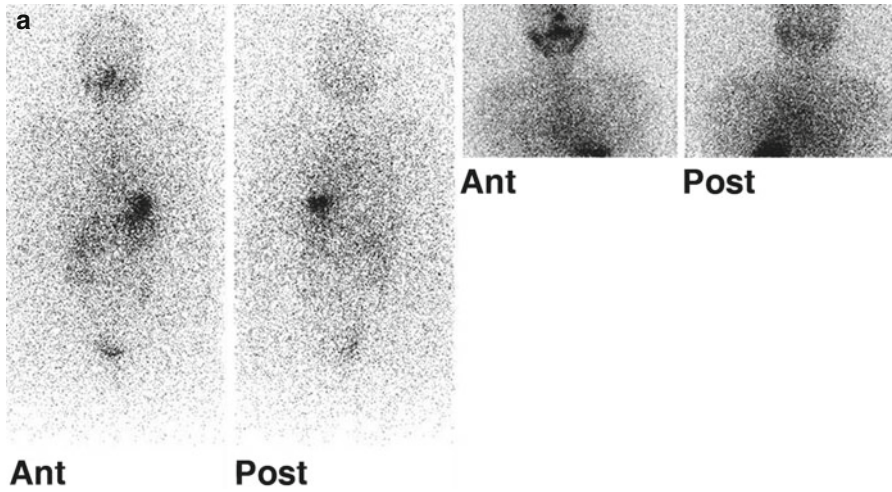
Diagnostic I^{131} scintigraphy anterior and posterior whole-body and spot planar images of a 64-year-old female patient with papillary thyroid carcinoma (TSH, 98 uIU/ml; Tg, 278 ng/ml; anti-Tg Ab <20 IU/ml) shows radioiodine uptake consistent with residual disease in the neck region (*arrowhead*) as well as bilateral lung metastases (*arrows*). *ant* anterior, *post* posterior
